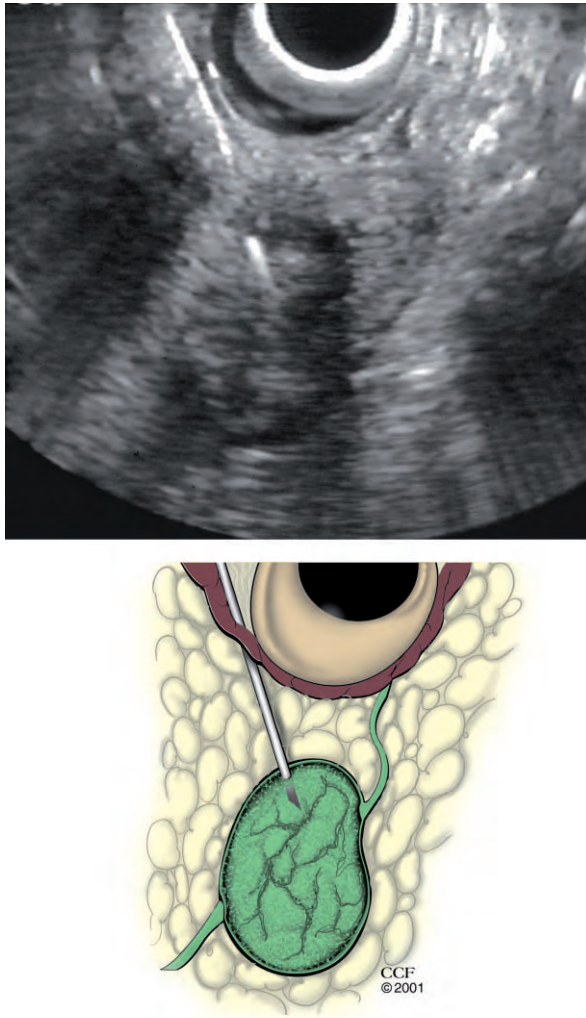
Esophageal ultrasound fine-needle aspiration (FNA) of an N1 regional lymph node. *Upper*, Ultrasound image with a needle passed through the esophageal wall and into the N1 node. *Lower*, An N1 regional lymph node undergoing FNA under curvilinear electronic endoscopic examination.
